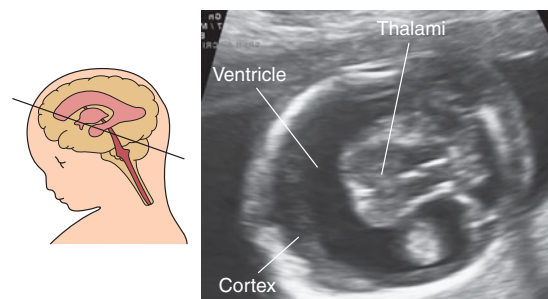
Most cases of alobar holoprosencephaly seen around mid-gestation will appear like this: In an axial scan at the level of the thalami, there is no midline echo, and a crescent-shaped ventricular cavity is seen between the anterior frontal cortex and the posterior bulb-shaped thalami. The posterior fossa may be normal. (Reproduced, with permission, from *Atlas of Obstetric Ultrasound*, 2009. The Global Library of Women's Medicine. www.glowm.com.)
